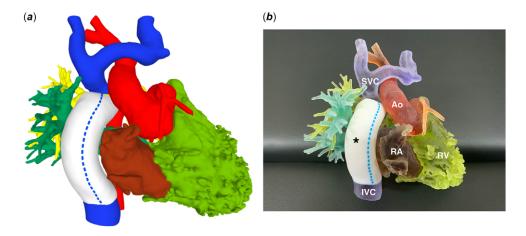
A 3D printed model of mitral atresia which was created using CT data obtained from a 31-month-old patient who underwent extracardiac conduit Fontan operation. (*a*) A CAD image. The extracardiac conduit was artificially expressed as similar to the actual graft used to increase its 'realness'. (*b*) A 3D printed blood pool model. The extracardiac conduit (an asterisk) looks similar to the commercially available graft used for Fontan operation. 3D = three-dimensional; Ao = aorta; CAD = computer-aided design; CT = computed tomography; IVC = inferior caval vein; RA = right atrium; RV = right ventricle; SVC = superior caval vein.
